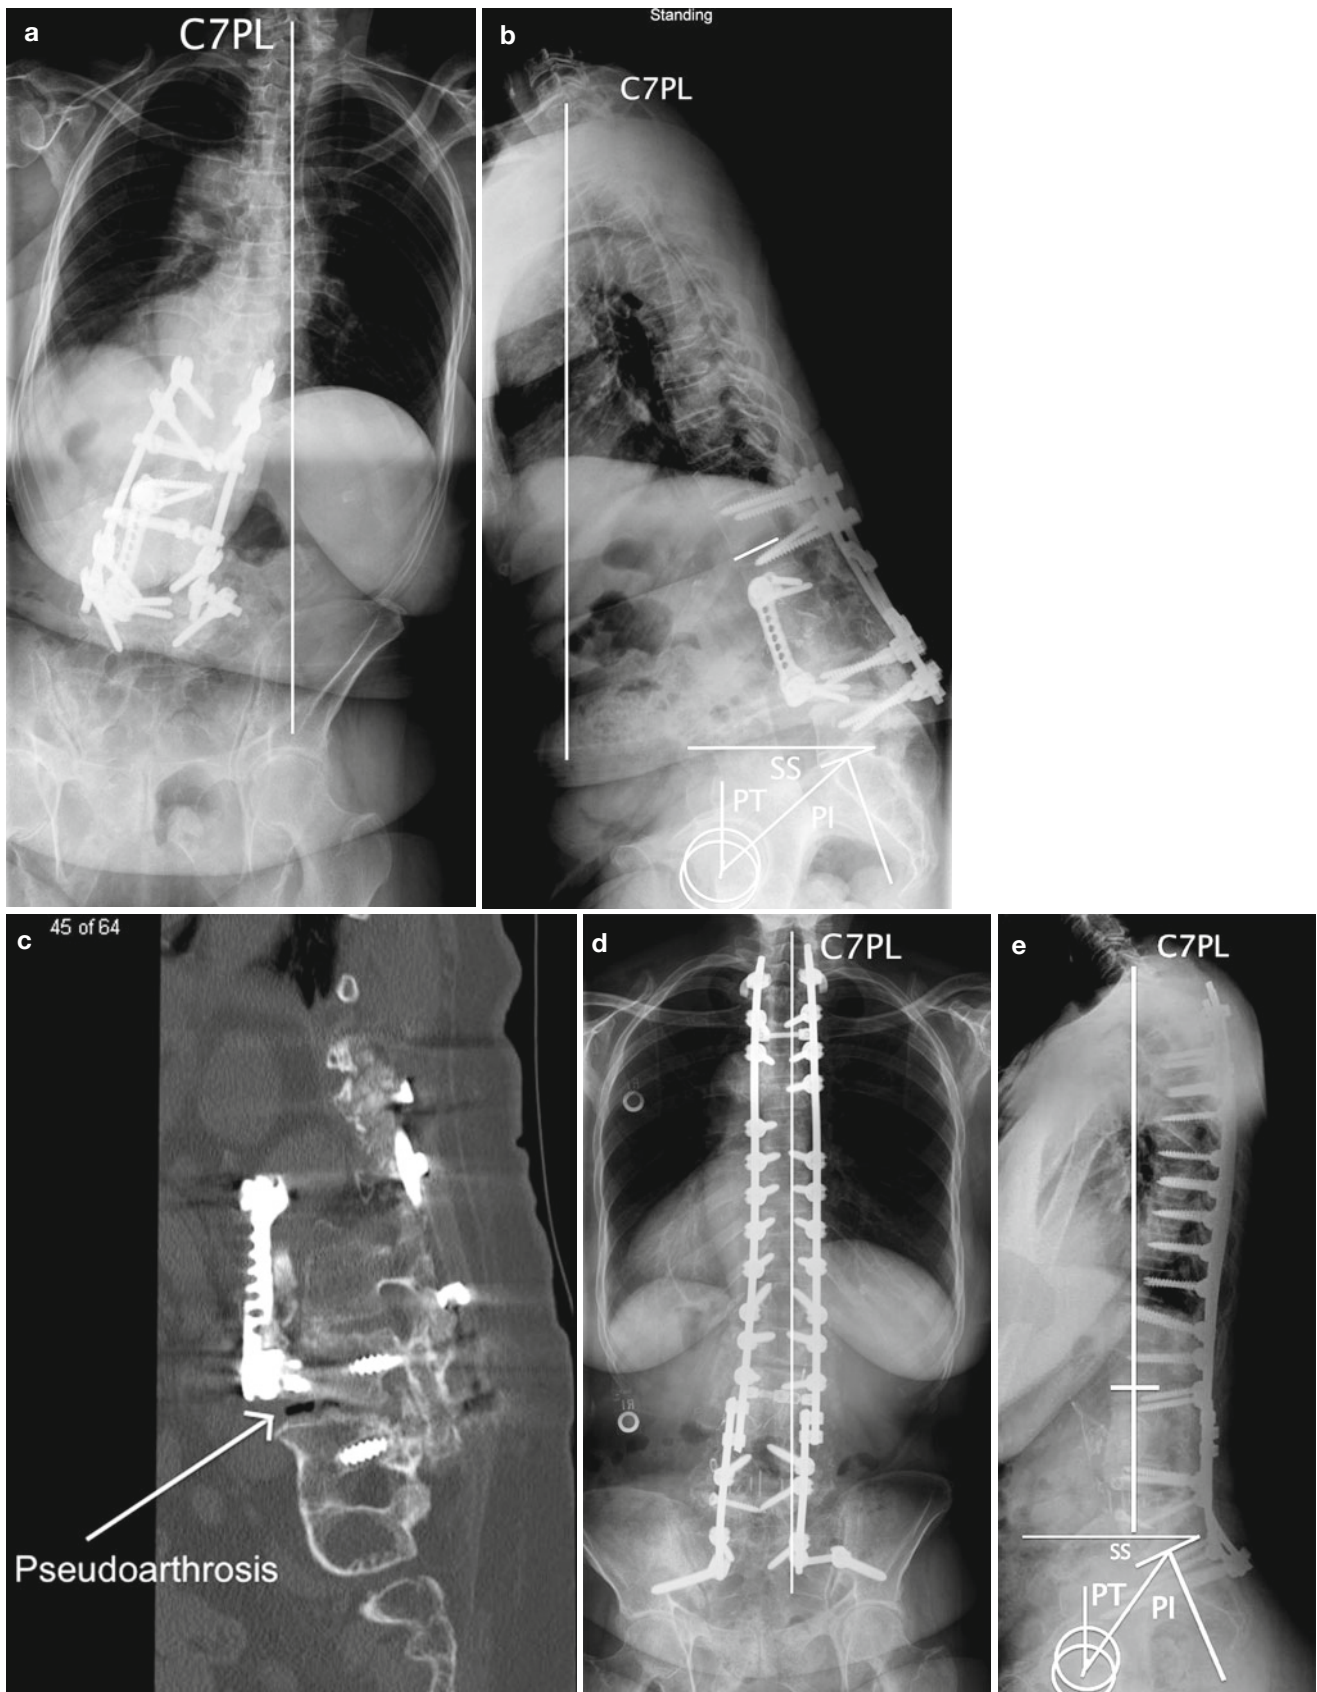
(a, b) AP and lateral preoperative radiographs of a 76-year-old female with previous failed open anterior spinal fusion (L2–L4) and posterior spinal fusion (T12–L5) with an L4–L5 pseudoarthrosis (c) and severe coronal (120 mm) and sagittal (+215 mm) imbalance and abnormal pelvic
